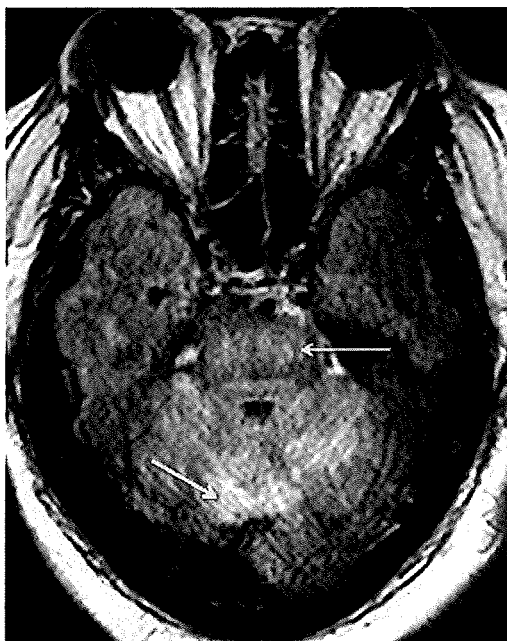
Isolated posterior fossa PRES. Axial FLAIR image shows FLAIR hyperintensity in the cerebellar hemispheres, cerebellar vermis, and pons (arrows). The remainder of the brain (not shown) was unremarkable.
